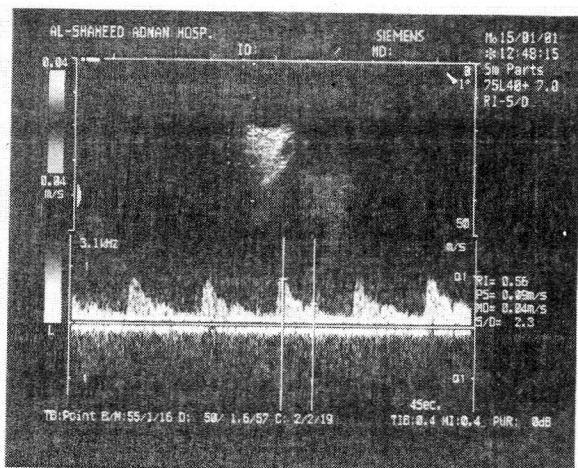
Posterior ciliary artery (Normal pulsated Doppler waveform).
